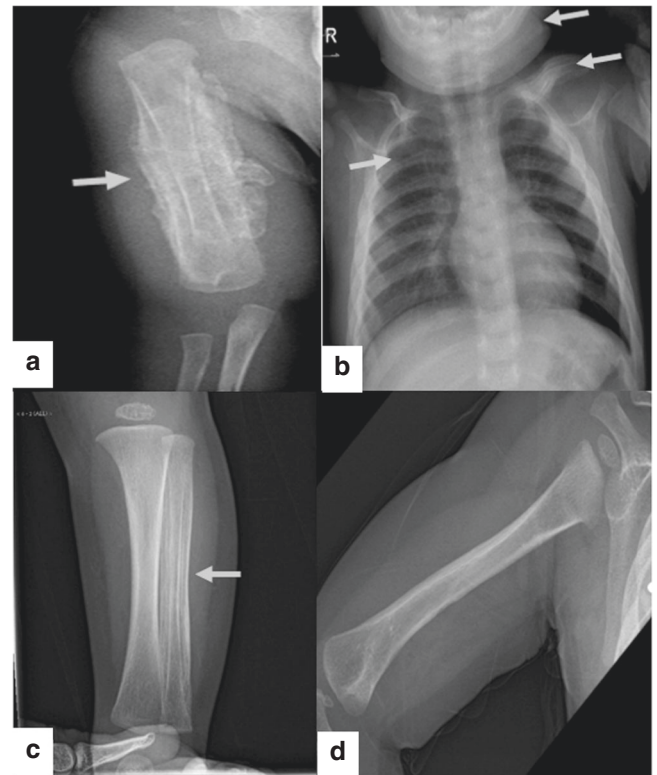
Patient's radiographic examinations. a Periosteal reaction along the entire shaft of the right humerus. b Periosteal reaction along the left clavicle, ribs, and mandible. c Periosteal reaction along the fibula. d Complete periosteal resolution of the humerus
